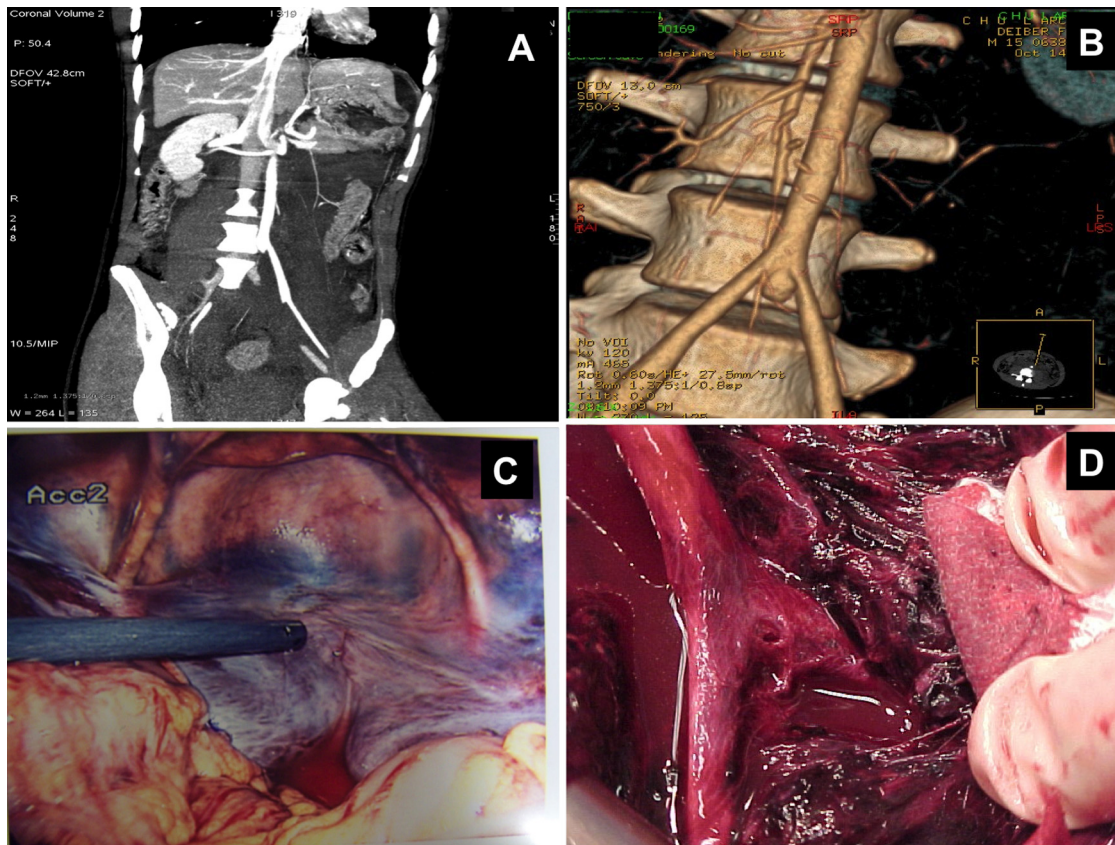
Case 1. (A) Multiplanar reconstruction CT angiography showing contrast material bulging from the aortic lumen. (B) Volume rendering CT showing the post-traumatic aortic false aneurysm. (C) Zone-III retroperitoneal haematoma as noted during laparoscopy. (D) The aortic rupture site evidenced at autopsy.
